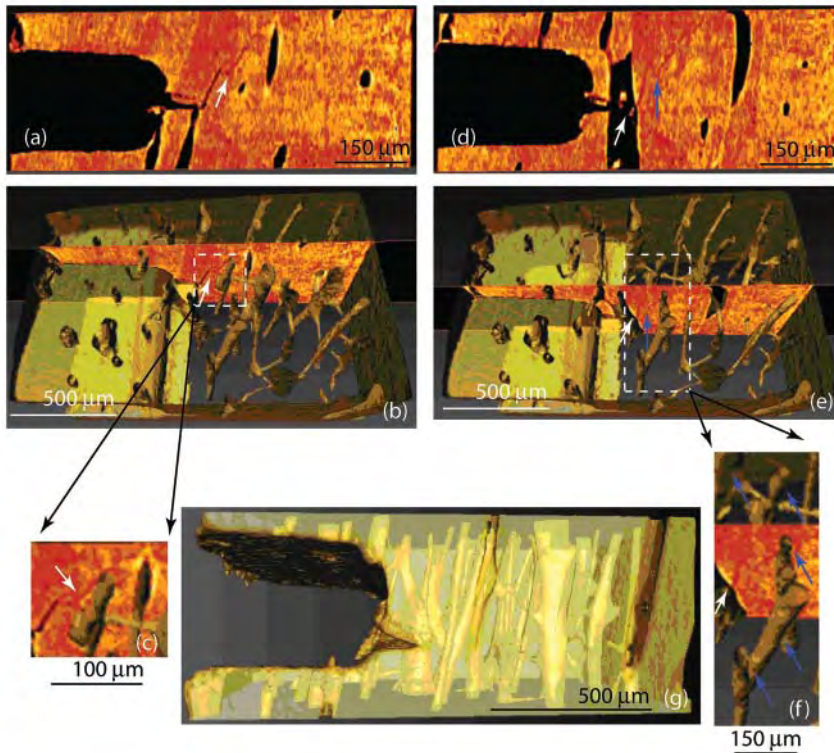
X-ray computed tomography images of a stable crack in human cortical bone in the transverse orientation. Panels (a–c) and (d–f) each show a two-dimensional (2-D) slice through the sample, a three-dimensional (3-D) image containing the slice, and a magnified view of a region of interest. A 3-D image of the entire volume of interest is shown in (g). In (a), a white arrow indicates a deflection that occurs before the crack encounters a Haversian canal, which appears as a black ellipse. The region of interest of this deflection is bounded by a box in (b) and the deflection is again highlighted with a white arrow. In (c), the deflection coincides with a Haversian canal at a different depth in the sample. Panels (d) and (e) show that at this depth the crack grows off of the notch at a different angle than the slice shown in (a), indicated by a white arrow, and that this angle corresponds to the edge of the Haversian canal at that depth. The crack undergoes three radical changes in direction in (d) and the blue arrow in (d) and (e) indicates two of these changes. The region of interest in (e) given by the white box is shown in (f). In (f) the white arrow again indicates that different angle of initial crack growth; the blue arrows indicate Haversian canals that could be exerting the influence to cause the multiple deflections of the crack as seen in (d).
